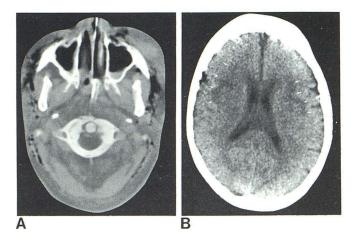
Case 6, 79-year-old woman with pneumomediastinum and secondary hypotension resulting from car accident. A, Initial CT scan on day of accident. Abundant subcutaneous emphysema from dissecting pneumomediastinum. B, Another level. Subtle, low-density areas (arrows) in watershed regions bilaterally. Sulci are effaced, especially if patient's age is considered.
